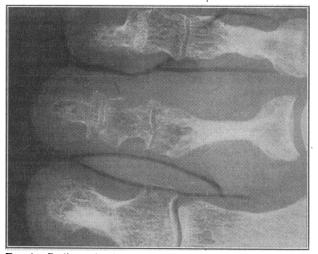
Radiograph of right foot of Case A, Table I. Destruction of cortical and medullary bone is seen most obviously in the middle phalanx of the second toe. (By courtesy of Drs. R. J. Cairns and J. D. Craig.)
